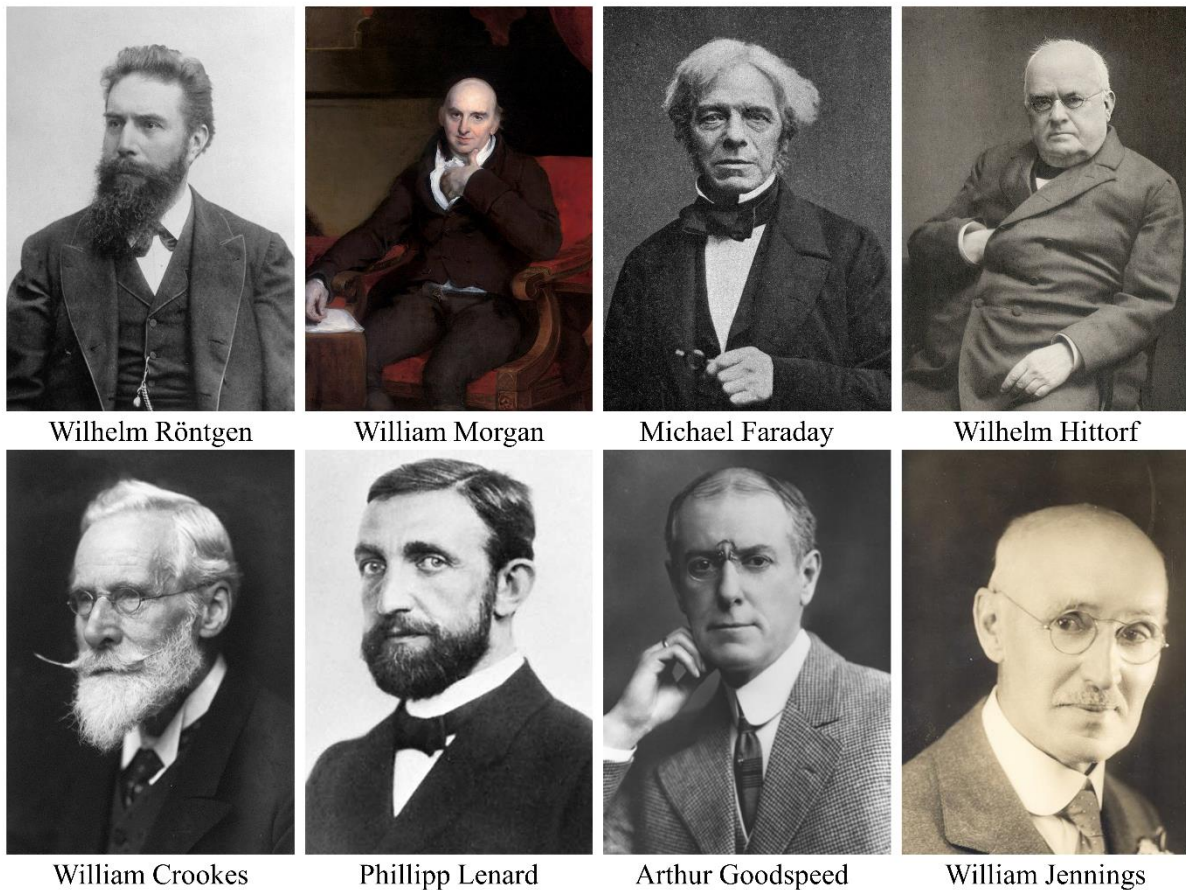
Non-exhaustive overview of pioneers in the discovery of X-rays. Public domain.
